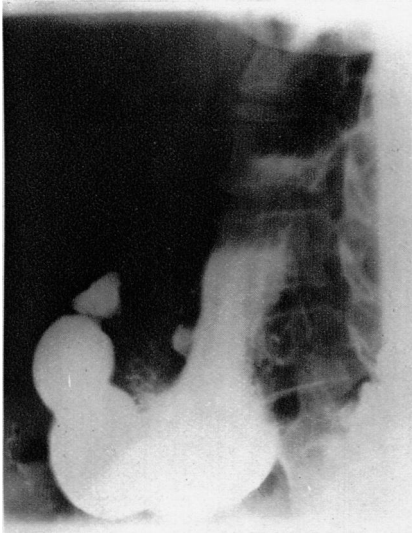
Radiograph showing penetrating ulcer on middle of lesser curvature.
